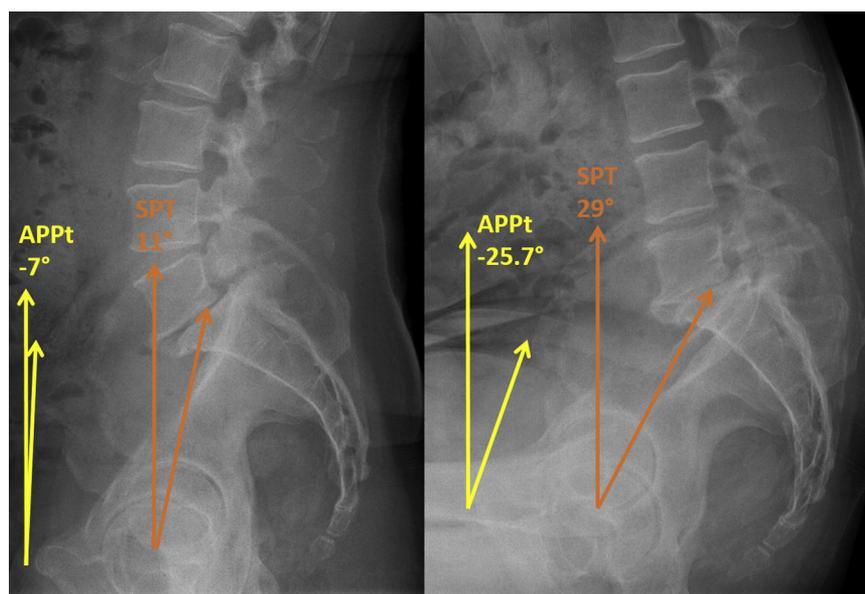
Lateral radiographs demonstrating the relationship between pelvic tilt and postural change. As the patient moves from a standing (left) to a seated (right) posture, posterior pelvic tilt (pelvic retroversion) increases, which is represented by an increase in SPT and a decrease in APPt.
